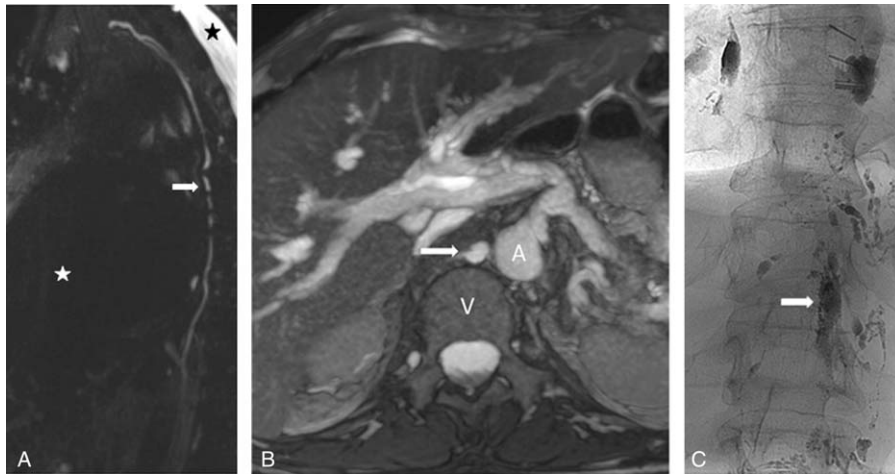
MR and fluoroscopic lymphangiography images of the central lymphatic system in 2 different patients demonstrating normal anatomy. A, Sagittal maximum intensity projection (MIP) reconstruction of T2-weighted MRL images in a 33-year-old patient demonstrates normal anatomy of a single thoracic duct (white arrow) as it courses through the thorax. Limited anatomic landmarks are noted on this sequence, as the lungs are of low signal (white star) and spinal fluid is bright on this sequence (black star). B, Axial maximum intensity projection (MIP) reconstruction of balanced gradient images in a 56-year-old patient at the level of T12-L1 demonstrates normal anatomy and location of the retroperitoneal cisterna chyli (white arrow), located immediately anterior to an upper lumbar vertebral body (V) and to the right of the aorta (A). C, Single oblique image of direct intranodal lymphangiogram in a 33-year-old patient seen in image (A) using digital subtraction angiography (DSA) reveals an opacified cisterna chyli (white arrow) at the level of T12-L1. The cisterna chyli is left paramedian in location. The wide cisterna chyli was accessed percutaneously to catheterize and embolize the thoracic duct. Smaller tubular and nodular foci of contrast opacification are compatible with small intrathoracic and intraabdominal lymphatic vessels and lymph nodes, respectively.
